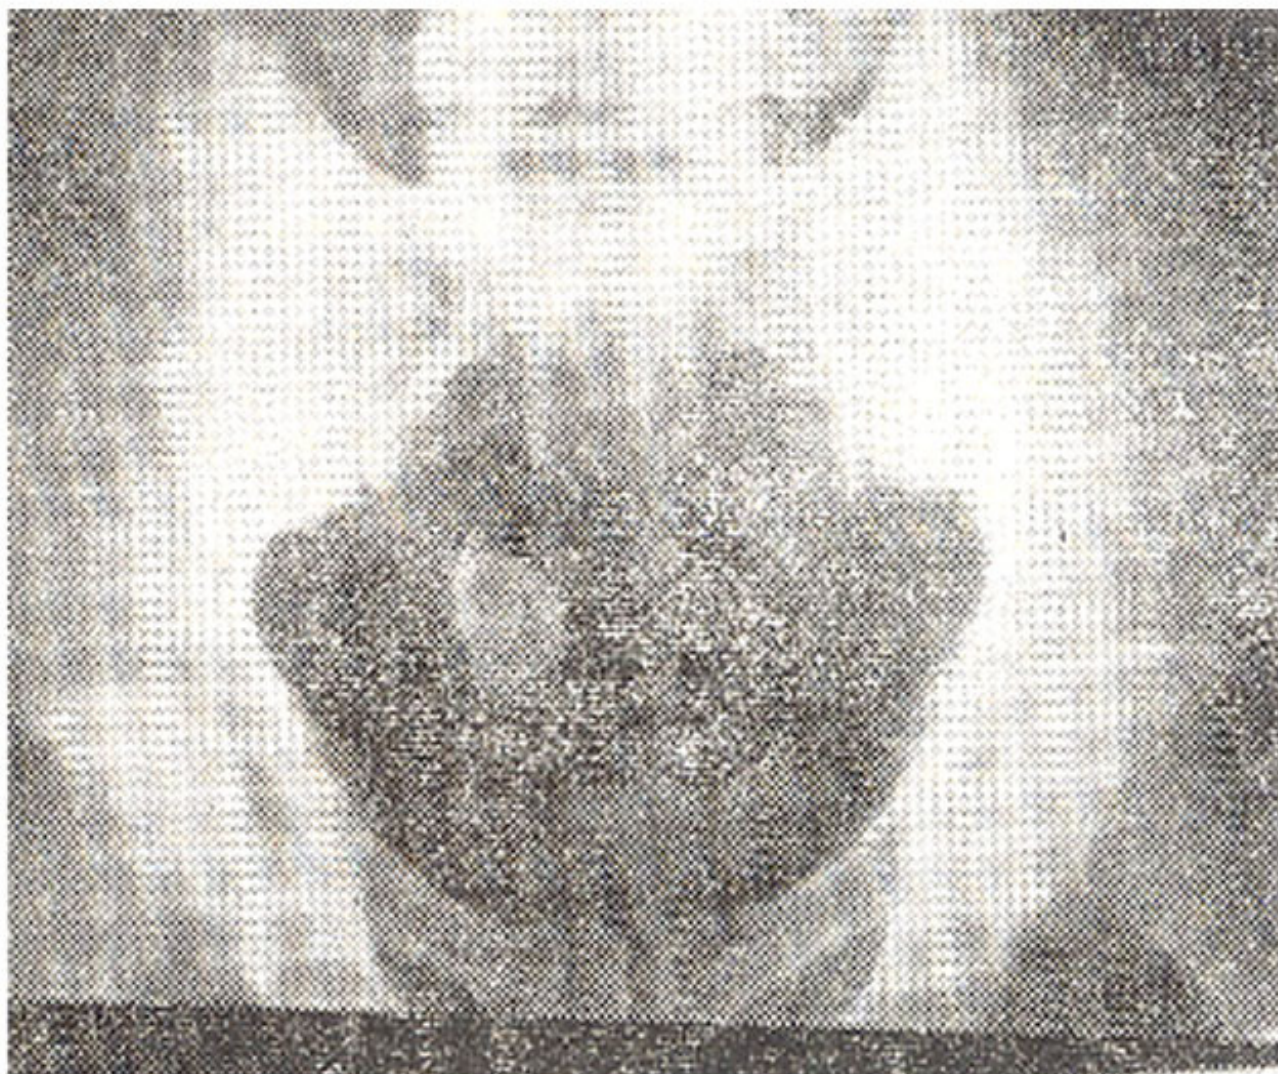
Plain X-ray abdomen. A radio-opaque shadow in front of the fourth sacral vertebrae.
